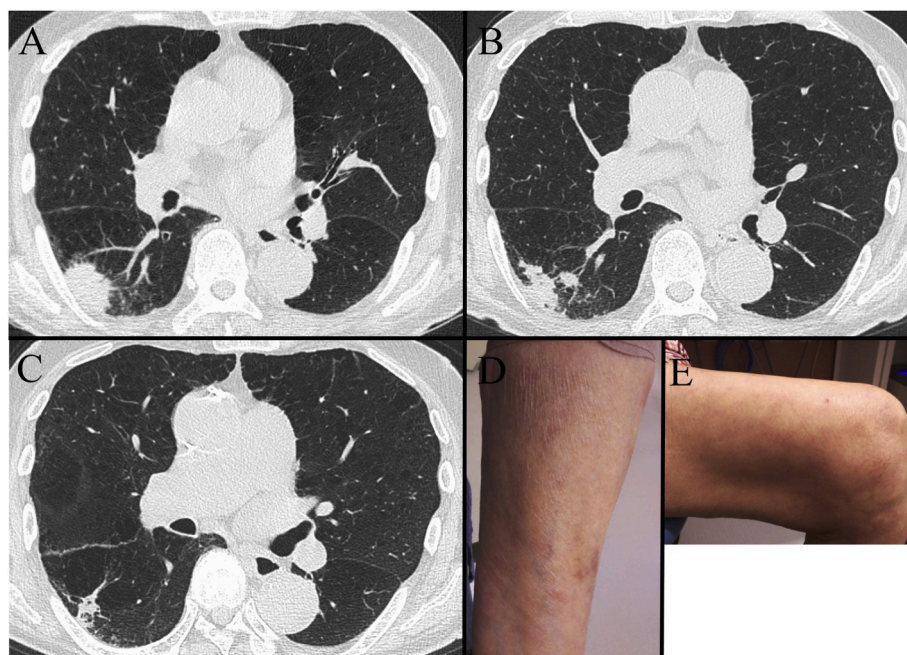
Chest computed tomography scan images and photographs of the skin rash. At the time of the lung cancer diagnosis, a tumor was found in the right lower lobe (A), and a new central metastasis to the lung was discovered after first-line chemotherapy (B). After the subsequent use of nivolumab, the tumor began to shrink (C), but pruritic eruptions appeared on the patient's extremities and trunk (D, E).
